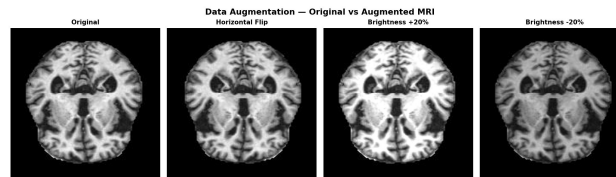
Data augmentation applied to a representative MRI scan: original image, horizontal flip, brightness increase (+20%), and brightness decrease (−20%).
